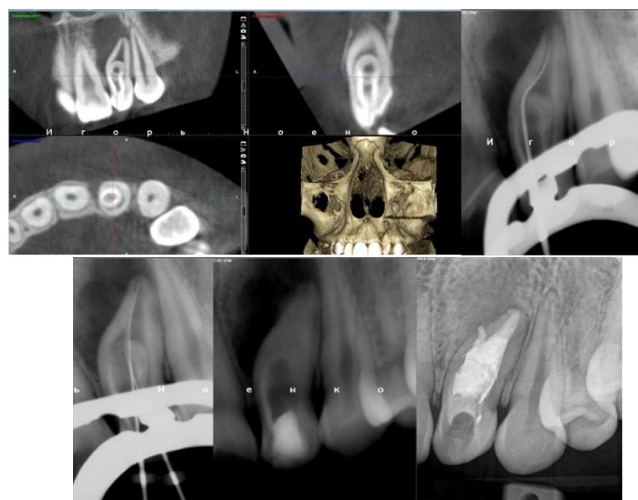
A periapical lesion in the 22 tooth with Type III Invagination. X-ray with files and recall 1 year.
